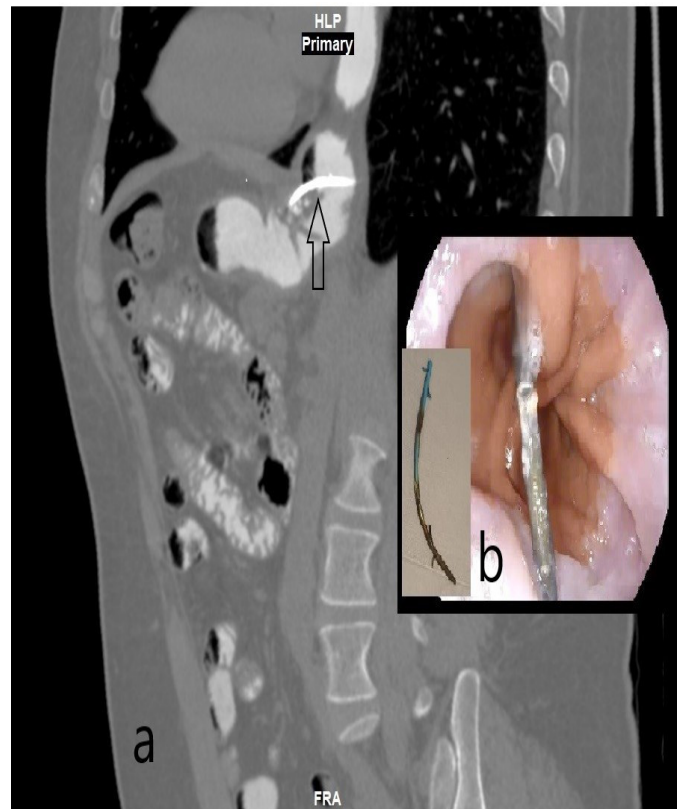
Contrast enhanced abdomino-pelvic multidetector-row computed tomography (MDCT) (a) showing the distal end of the endoprosthesis (arrow) in the peri-gastric area with no extravasation of the oral contrast and the proximal end partially migrated in the oesophageal lumen, With the corresponding aspect of the endoprosthesis on upper endoscopy before it was removed (b).
